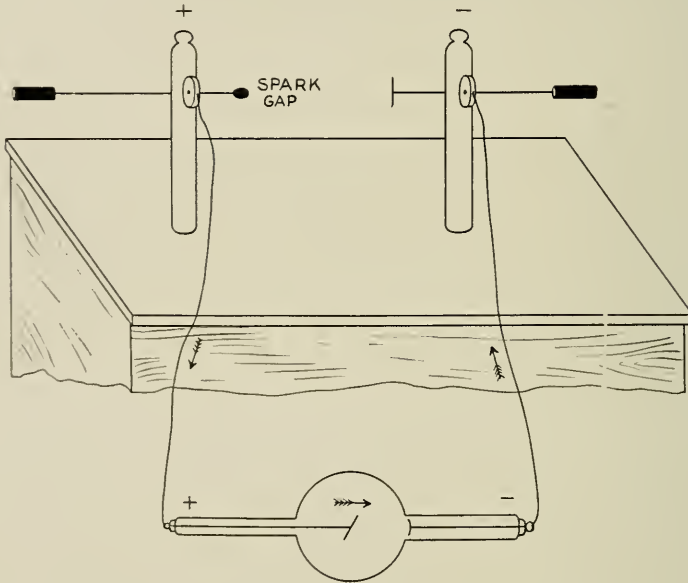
The X-ray tube connected with the induction coil.
